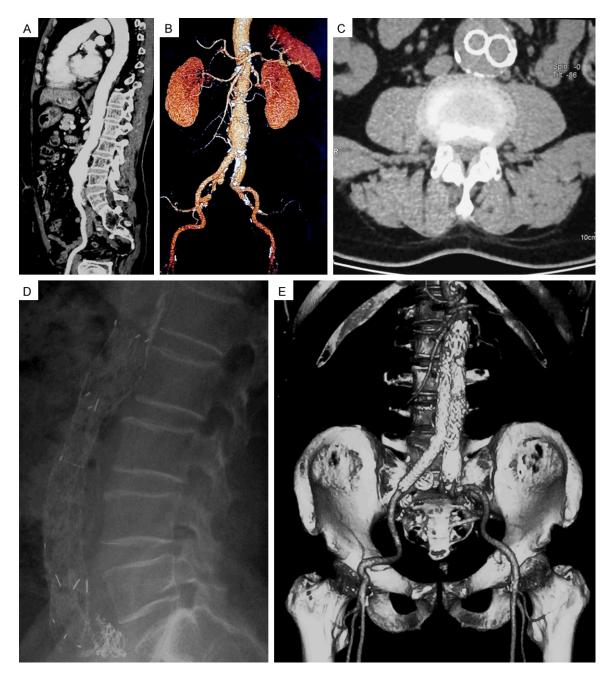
74-year-old male patient diagnosed as AAA. A, B: The sagittal image and 3-D reconstruction of preoperative CTA showed the AAA in the cauda equina region. C: Transverse image of lumbar CT showed the iliac branch stents and the slight lumbar stenosis at 12 m-follow-up after EVAR. D, E: The Lateral X-ray and 3-D reconstruction at 12 m follow-up after EVAR.
